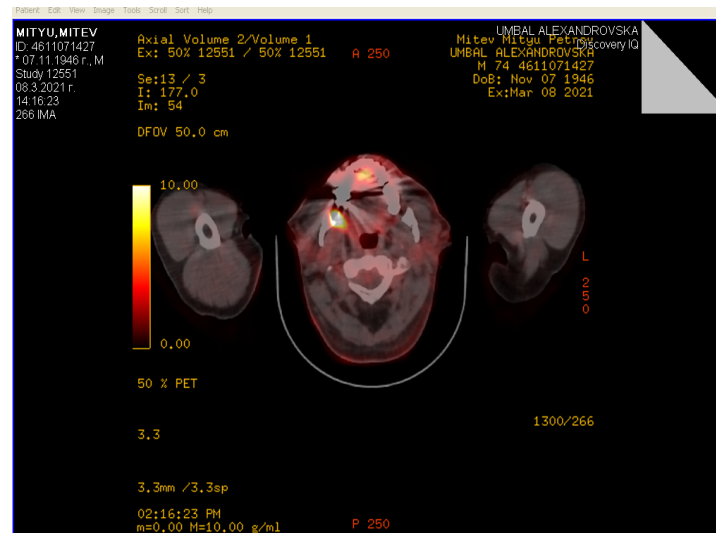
PET/CT image of the gingival metabolite active formation.
